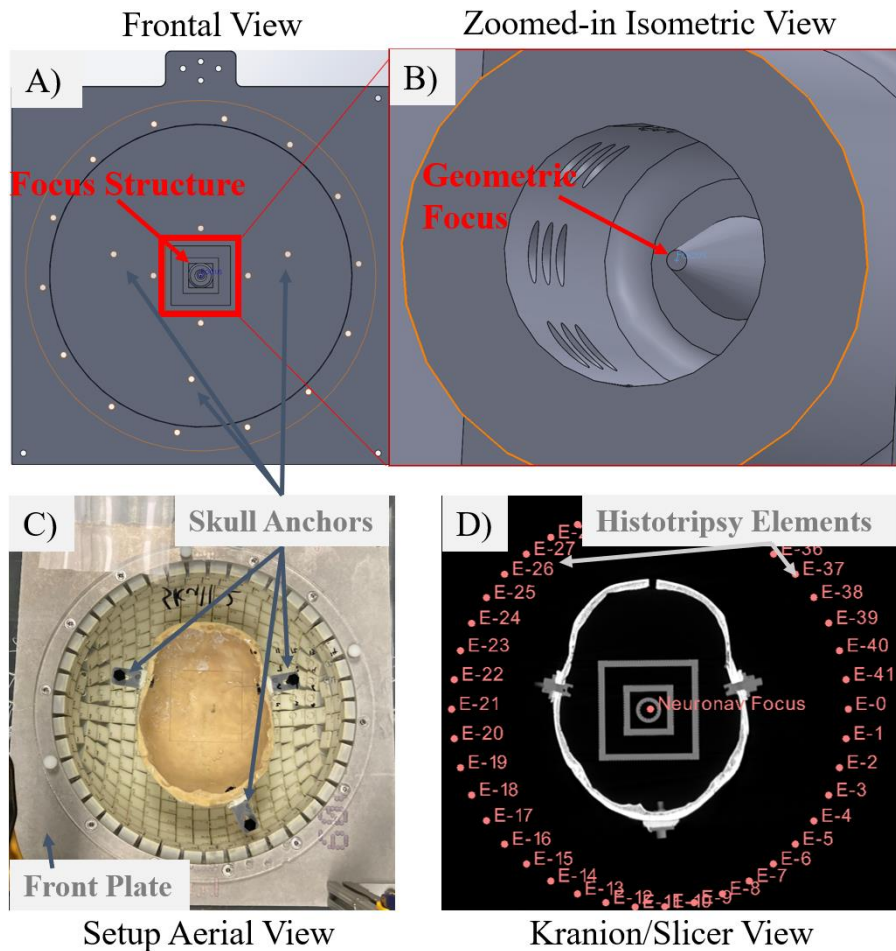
TRE evaluation setup. A focus structure (A & B) and a skull-holding acrylic plate were designed in SolidWorks and were 3D printed, and laser-cut, respectively. (A) and (B) provide a detailed view of the focus structure, and the setup view (C) provides how the setup can be positioned relative to the transducer front plate. The skull contained three L-brackets that allowed attachment to the acrylic plate and the acrylic plate connected to the histotripsy transducer front plate for mechanical co-registration. The skull anchors refer to the holes in the acrylic plate that attaches to the L-brackets of the skull. The Kranion/Slicer view (D) superimposes the co-registered element positions, the co-registered target (i.e. neuronavigation focus), and the CT of the skull and focus structure. The ‘neuronavigation focus’ depicted in (D) is the co-registered histotripsy focus from the TTI. Histotripsy array elements are denoted with E-#, where # is the number of the element.
